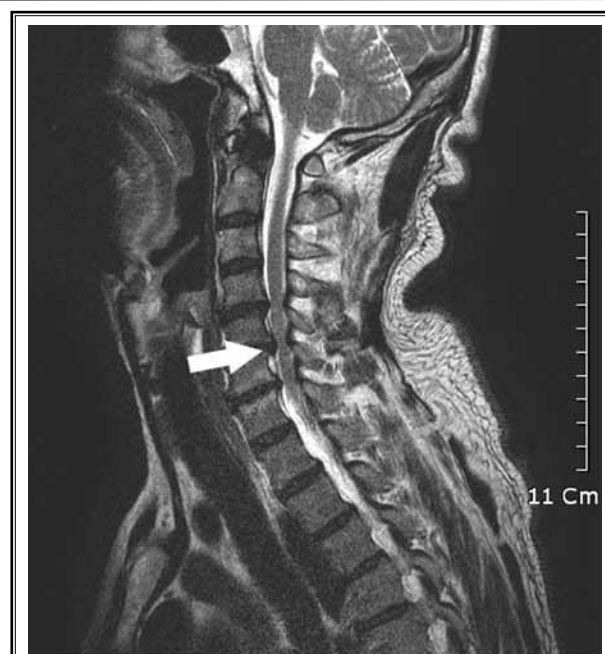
A 52-year-old man with cervical canal stenosis. Sagittal T2-weighted fast spin-echo image shows grade 3 cervical canal stenosis at the C5-6 level (arrow). The spinal canal is significantly narrowed at this level, and the signal intensity of the spinal cord is increased at the corresponding level.
